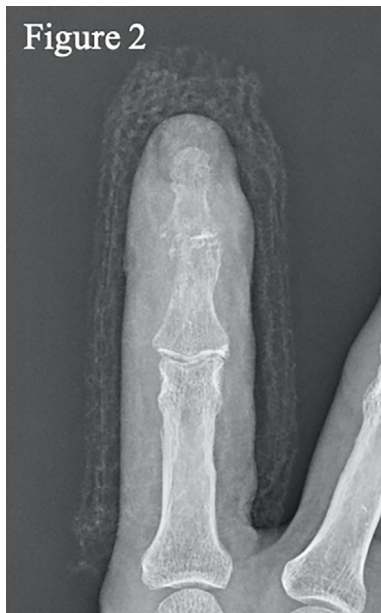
Anterior radiograph of the right index finger 5 days before the presentation.
